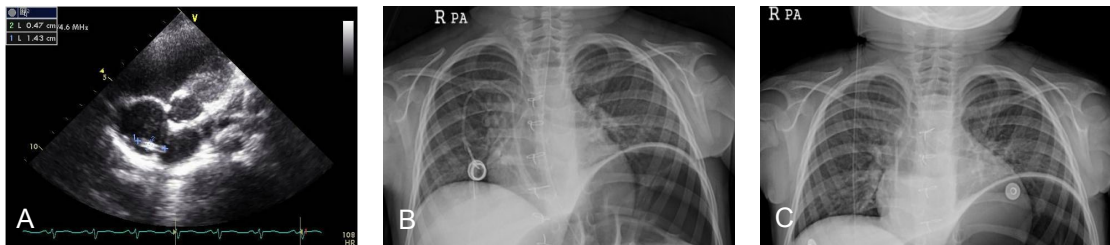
Remained TIVD with vegetation within RA after TIVD removal operation on echocardiogram
